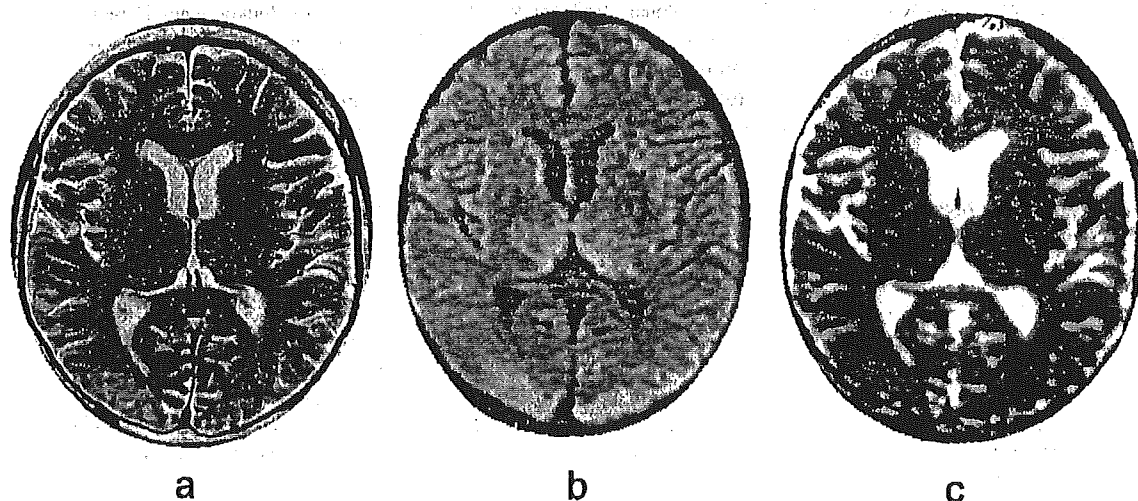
Neuroimaging of the brain. *a:* T₂-weighted magnetic resonance imaging. *b:* Diffusion-weighted magnetic resonance imaging. *a* and *b*, obtained on the day 8 after admission, show pale hyperintensity in both the frontal and posterior lobes involving both the subcortical white matter and gray matter. *c:* Apparent diffusion coefficient maps demonstrating hyperintensity in the same lesion.
